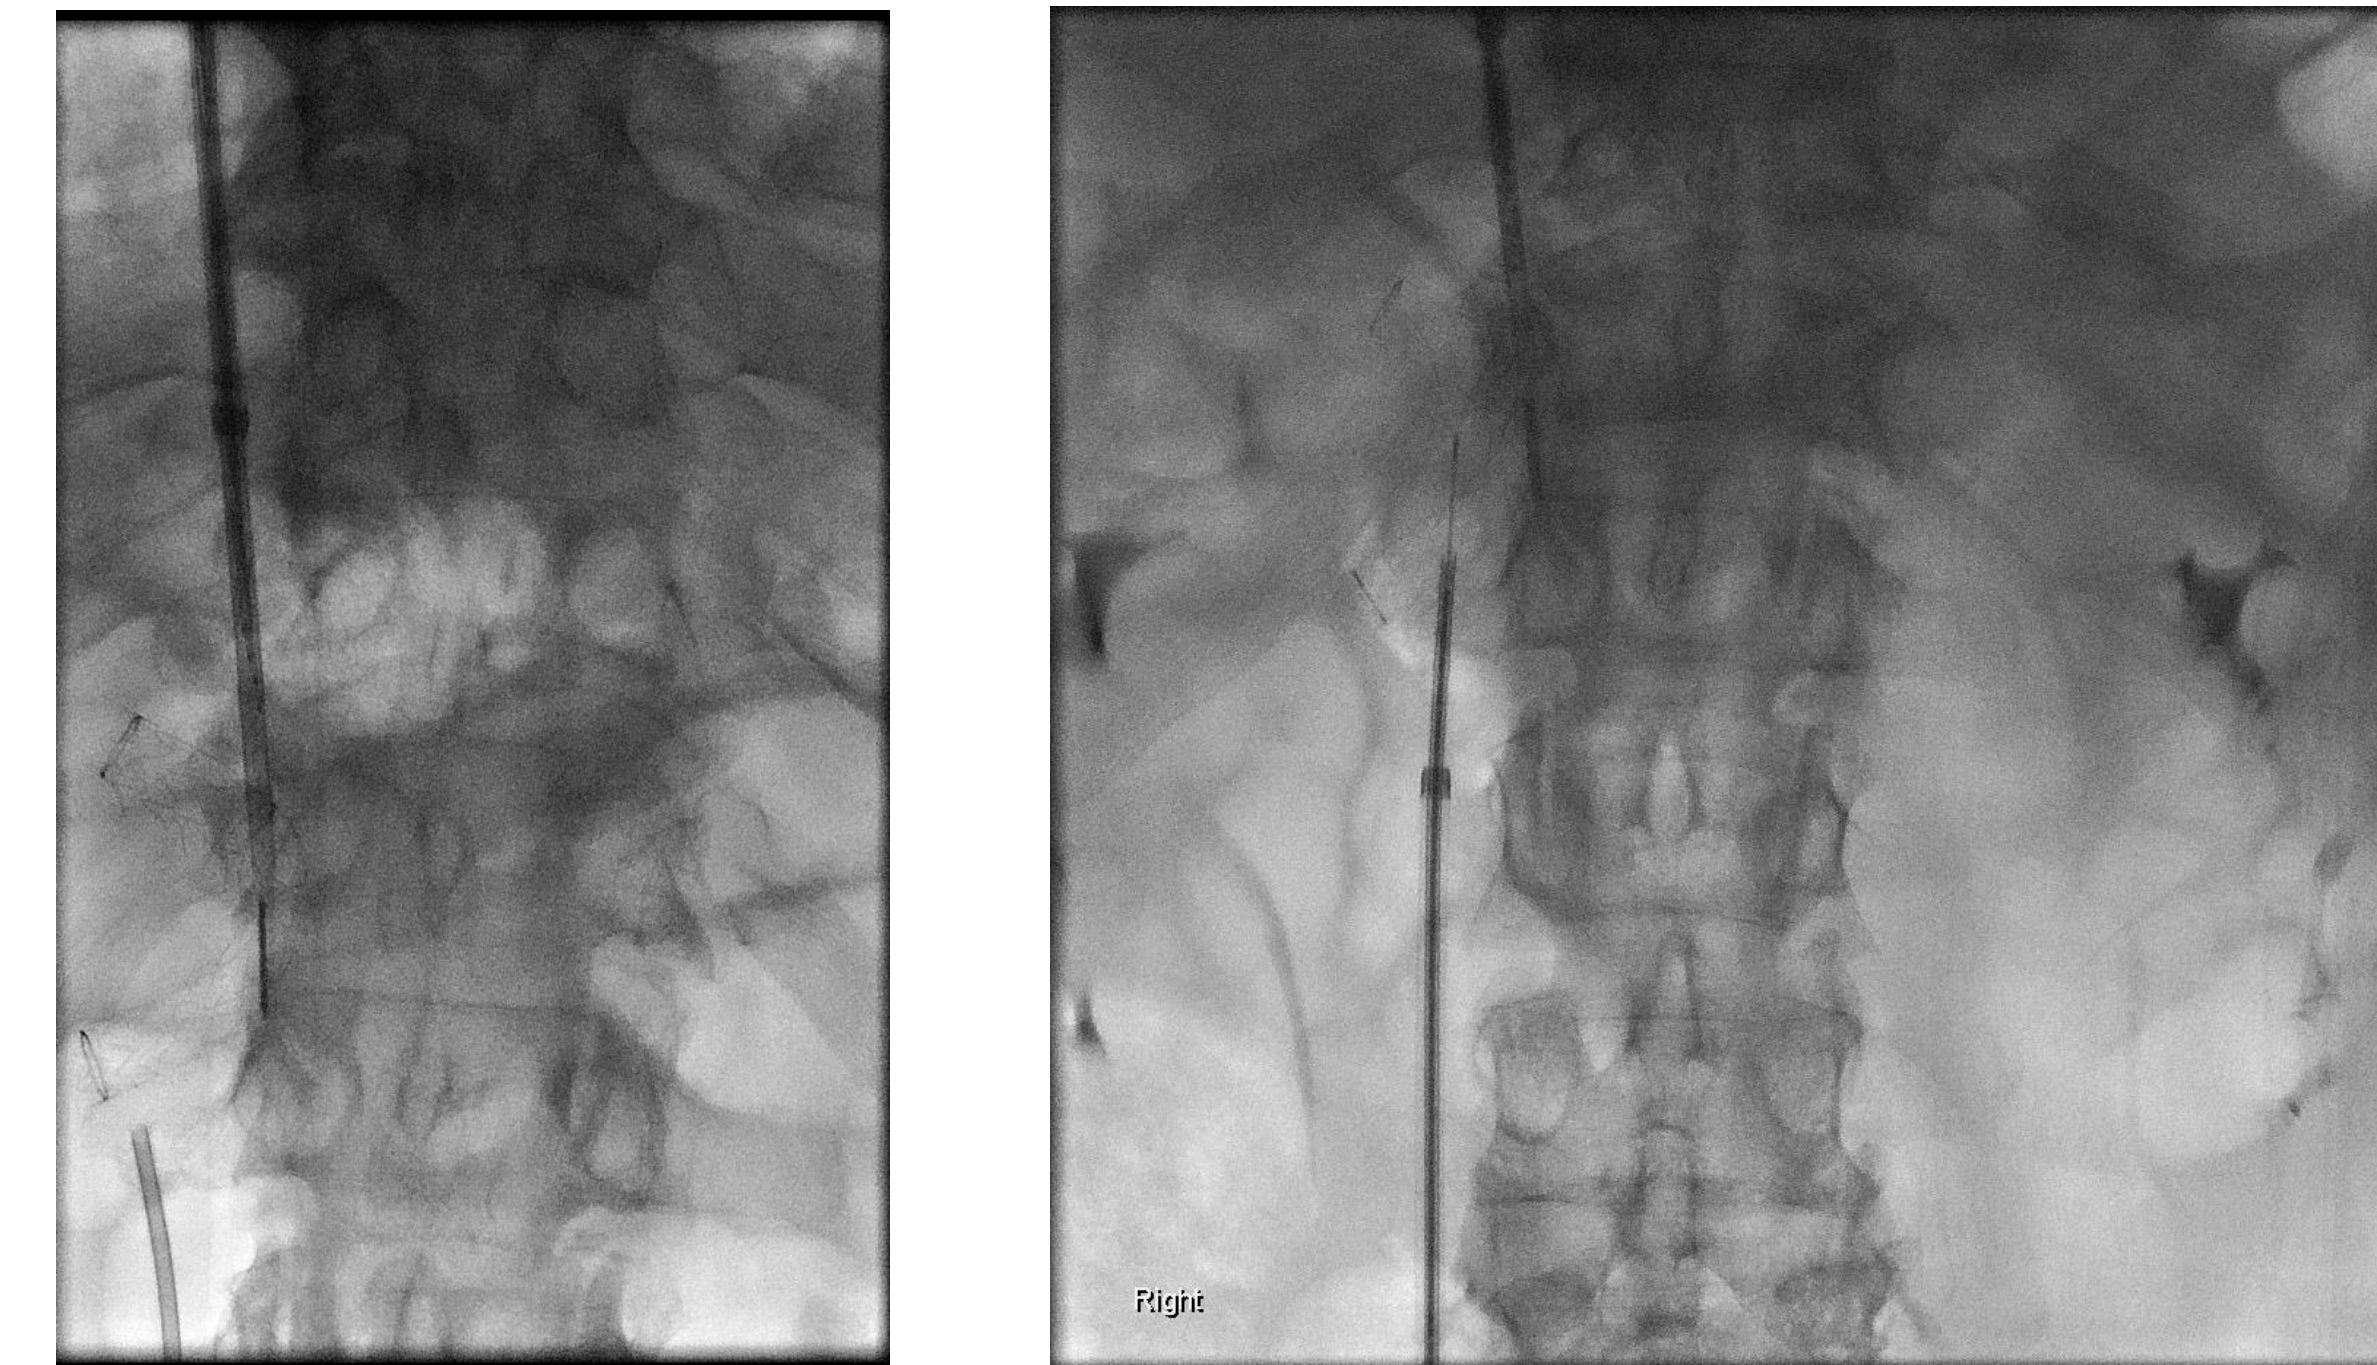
Intraoperative images demonstrating right internal jugular venous access for placement of an intracardiac echocardiography (ICE) catheter and right common femoral venous access for advancement of a transjugular biopsy set, with the pericaval lymph node identified and biopsied under ICE guidance.
